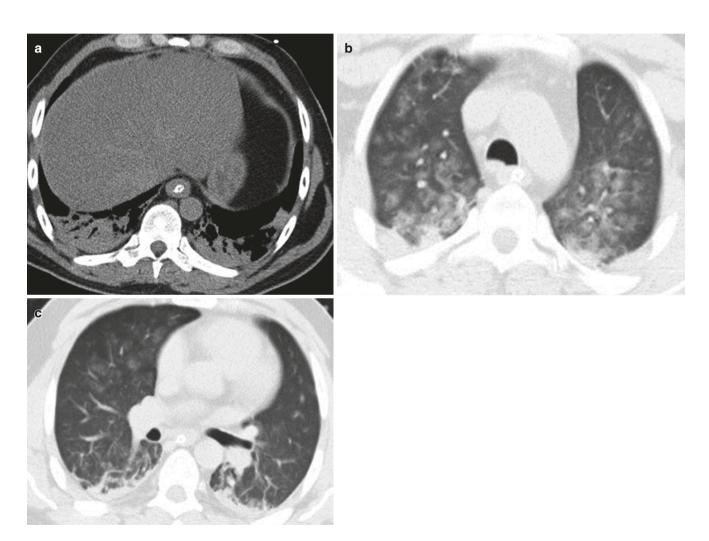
Nocardiosis in a 58-year-old man. (a) CT thorax axial image shows lower lobe consolidation. Axial CT images (b, c) show multiple ground-glass density nodules
